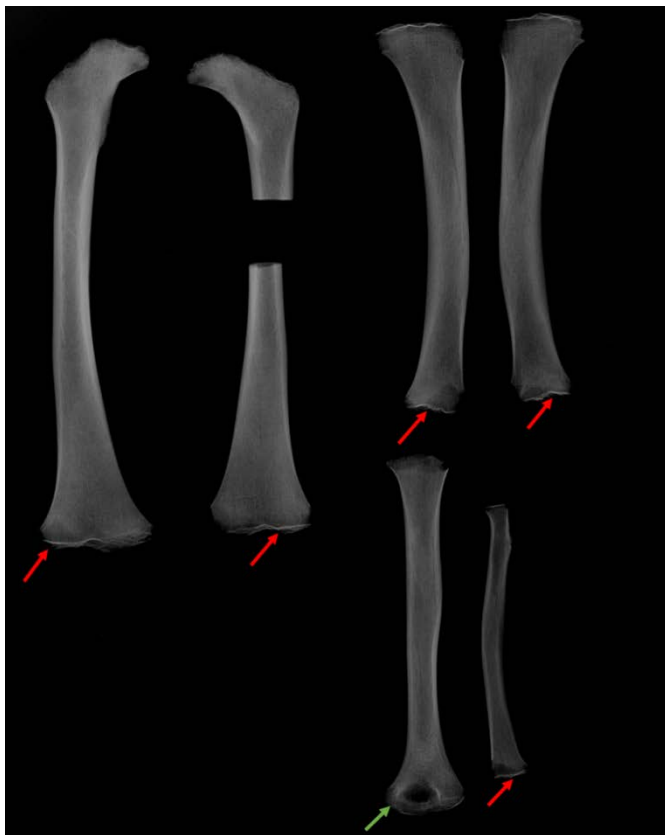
Radiograph of long bones from SCR 175 (femora, tibiae, left humerus, and left radius), showing radiographic features evaluated to determine whether vitamin D deficiency was active or healed. Deficiency in this individual is healed, based on features of the bone underlying the growth plates which has regained definition (indicated by the solid white lines, marked with red arrows), and do not show any of the fraying or lack of definition associated with active deficiency. The distal humerus has a less defined growth plate as a result of postmortem damage (green arrow).
